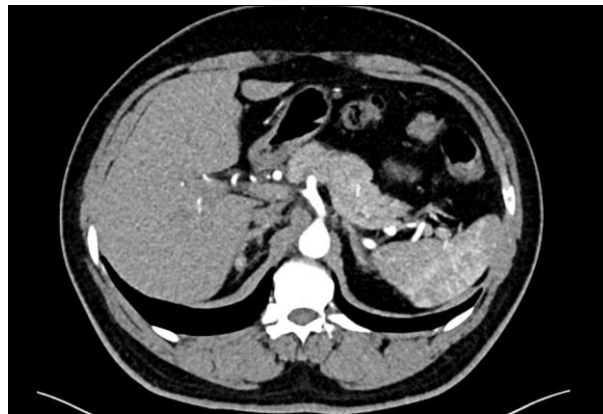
Adrenal Triphasic CT scan
